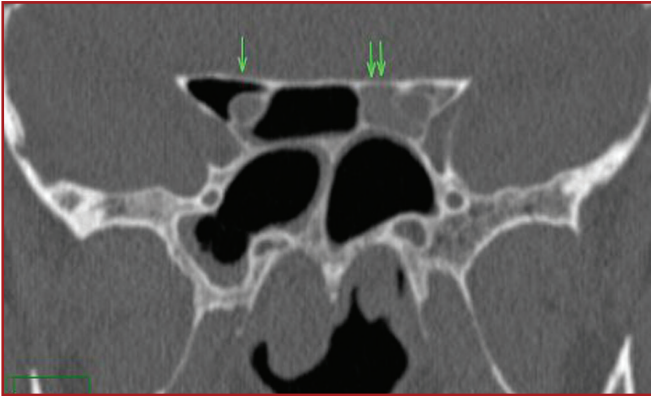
Pneumatization of the right anterior clinoid process and optic nerve protrusion (arrow) on coronal CT. Additionally, mucus-filled Onodi cell was seen on the left side (double arrow).
